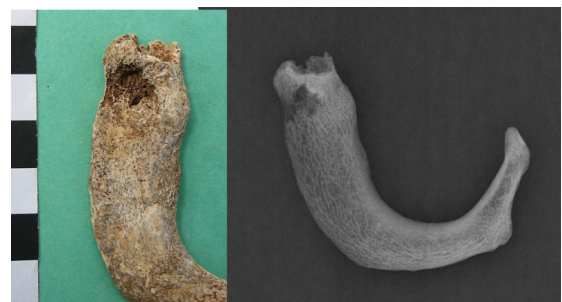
The first right costal bone showing small erosion penetrating in the subchondral bone (on the right) and X-ray (on the left)
